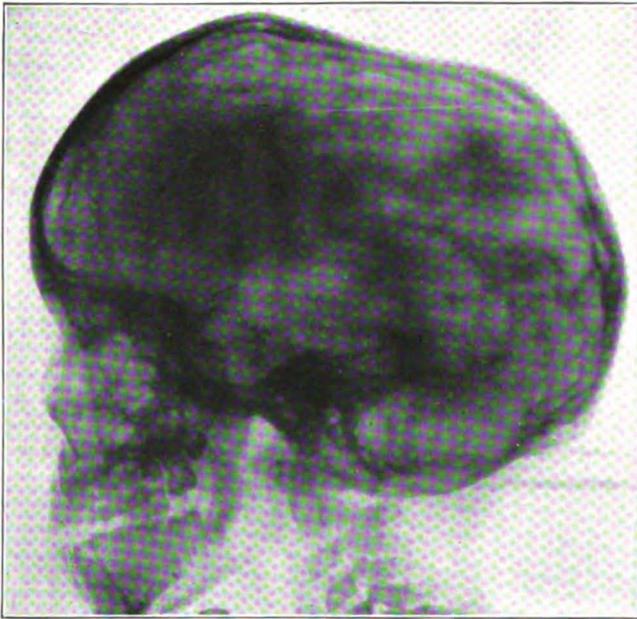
(Case 3).—Roentgenogram of profile: very large sella; distinct ridge forward.
